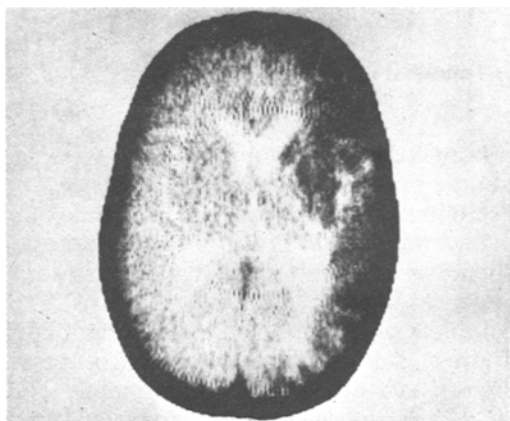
The CT scan which shows a massive infarct in the periphery of the right cerebral hemisphere.
